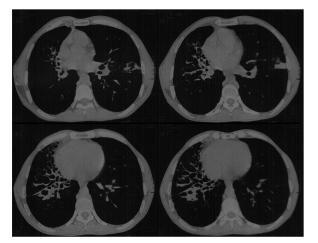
Computed tomography revealed bronchiectatic changes, hyperlucency of lower part of the right hemithorax
